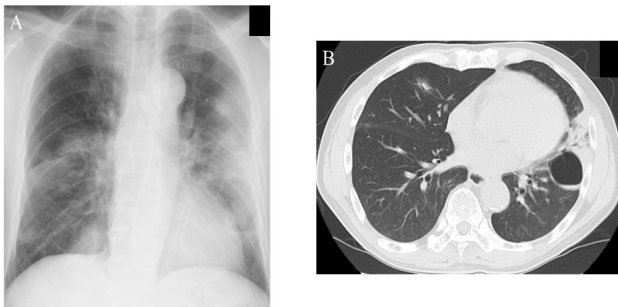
Cavitory shadow emerged in left S5 after BAL (A: Xp, B: CT).
